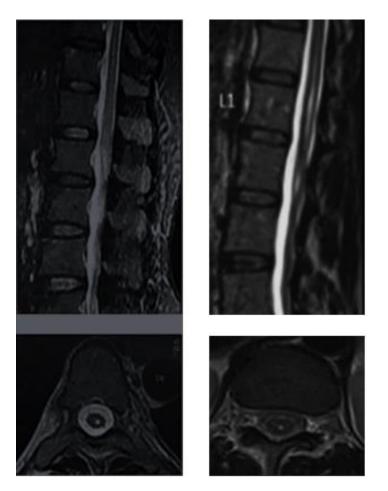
The lumbar MR scans of the first and second patients were shown on the right side and left side of the picture, respectively. As a result of injury to the spinal cord produced by lumbar puncture needle and administration of local anaesthetic agent, sagittal and axial T2 weighted MRI revealed cystic myelomalacia or syrinx inside the material of the conus–epiconus area of the spinal cord.
